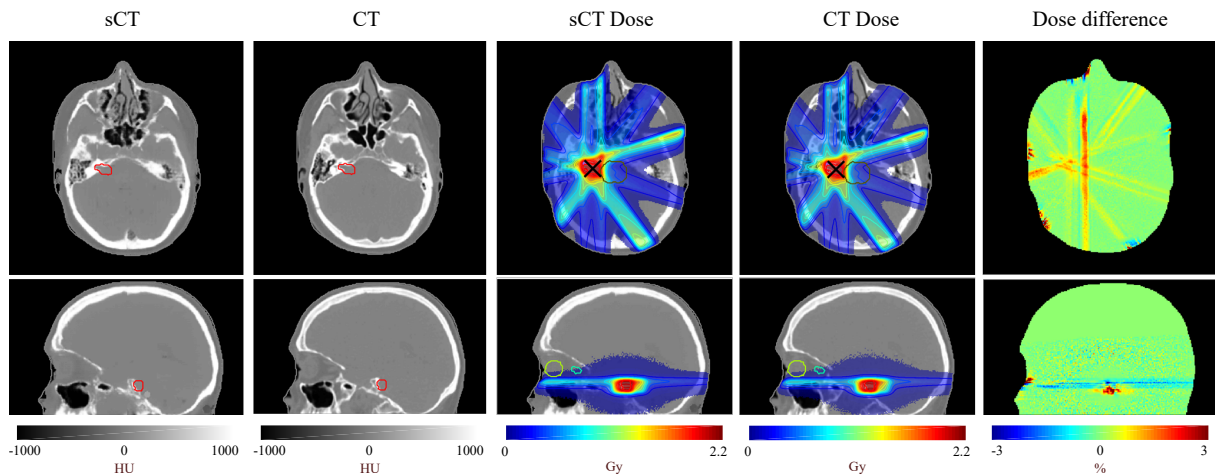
sCT, CT, dose calculated on the sCT and CT for the 5-beam IMRT plan and dose difference between the two for a representative patient with a vestibular schwannoma. Sagittal and axial views at the tumour isocentre plane.
